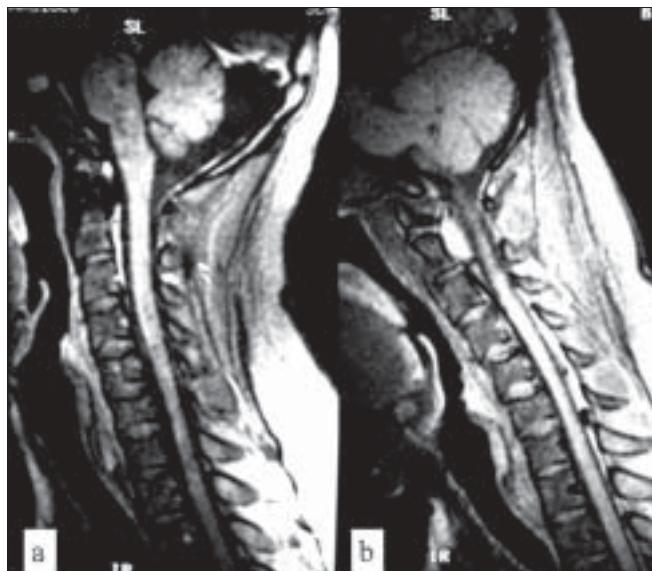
Neutral and flexion position post contrast fat saturated sagittal MRI images of patient no. 5 showing the anterior displacement of the dural sac and enhancing posterior epidural component with flow voids
